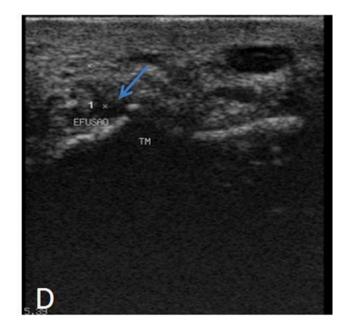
Ilustration of radiographic and ultrassonographic images of OCD in the intermediate crest of the tibia in D0 (A; C) and in D30 (B; D).
